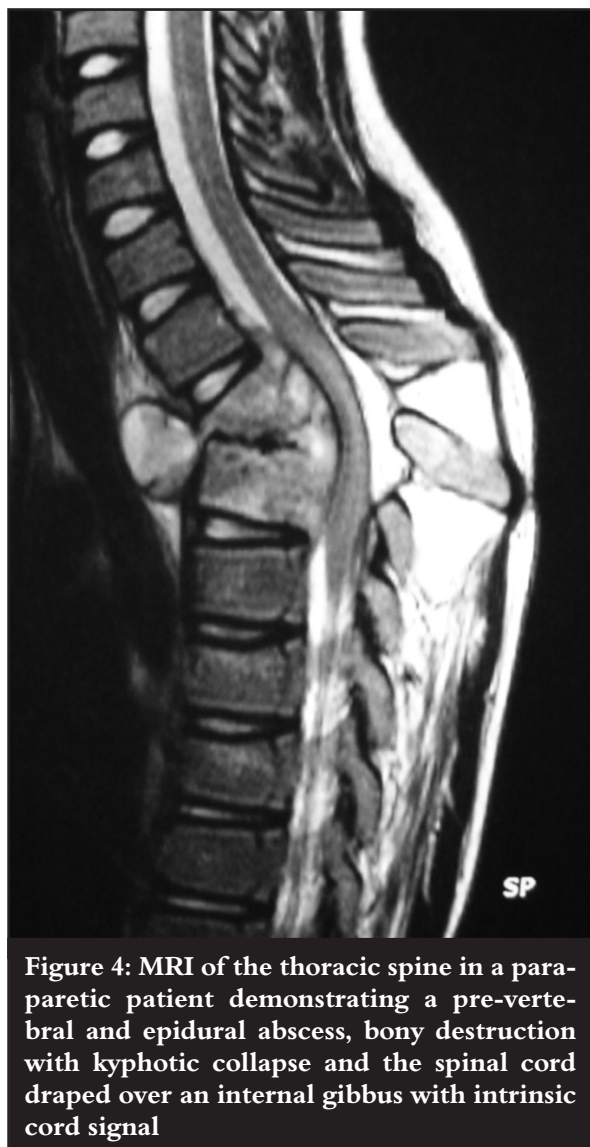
MRI of the thoracic spine in a paraparetic patient demonstrating a pre-vertebral and epidural abscess, bony destruction with kyphotic collapse and the spinal cord draped over an internal gibbus with intrinsic cord signal
